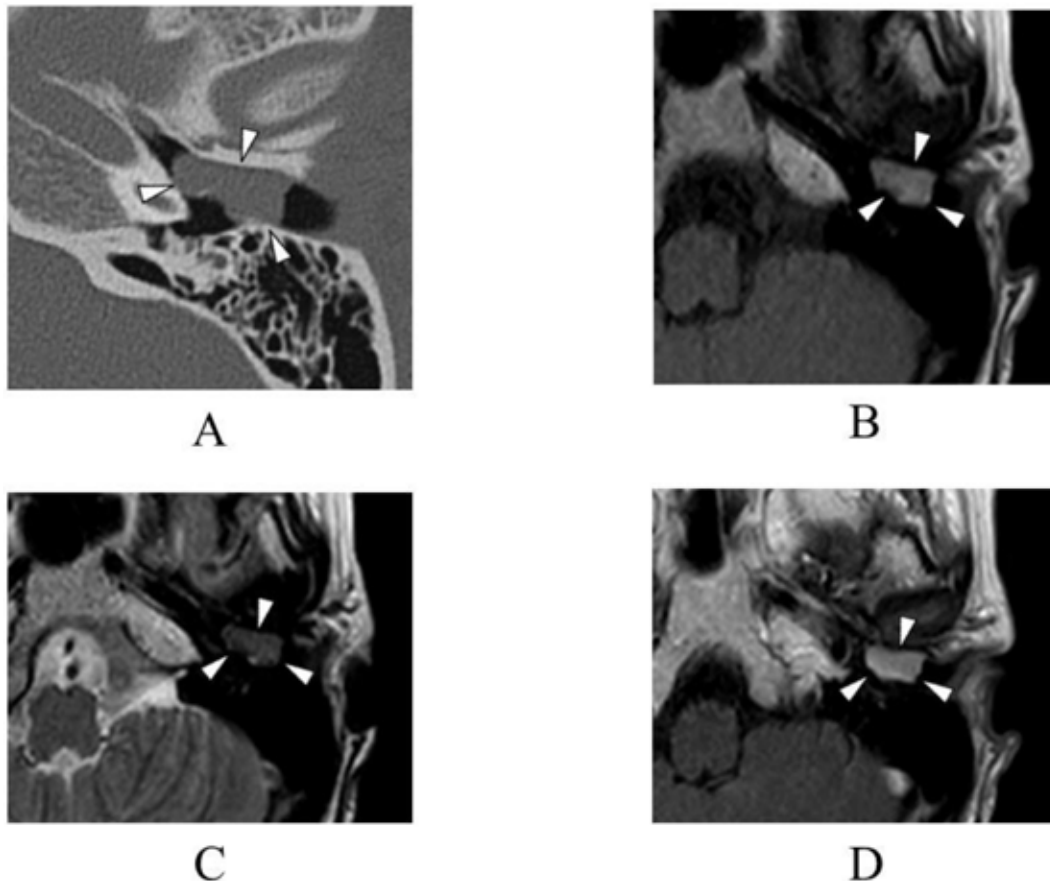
Computed tomography (CT) and Magnetic resonance (MR) images of the temporal bone in Case 2. The arrowheads show the tumor extension.
